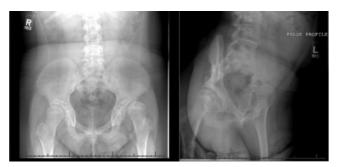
AP pelvis (left) and false profile left hip (right) radiographs demonstrating left hip dysplasia and subluxation.
